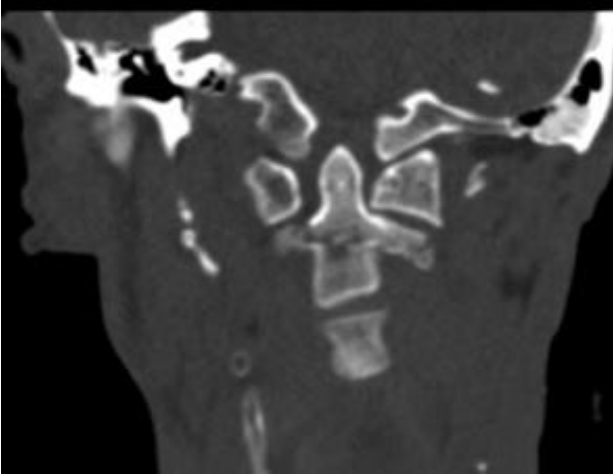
Preoperative Coronal Section CT
